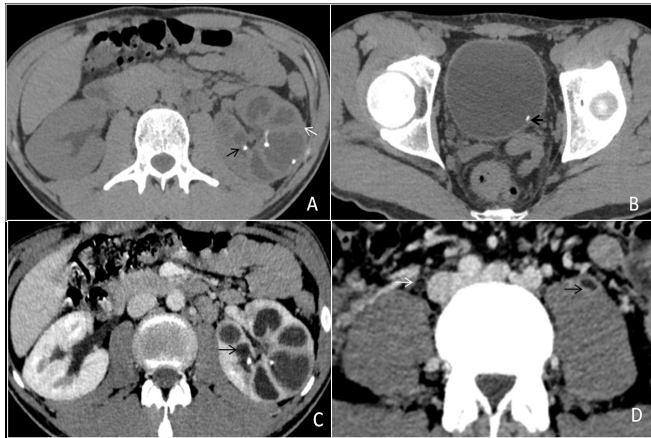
(A) A 40 years old male patient came to our hospital three months back. After initial investigations, he was diagnosed with genito-urinary tuberculosis and started on ATT, after which the patient improved symptomatically. However, after three months, he discontinued the treatment and again presented to us with burning micturition and increased frequency of urination. The patient underwent a CT scan which is depicting a relatively enlarged left kidney with fine calcification along the calyces (black arrow) and thinning of renal parenchyma (white arrow). (B) NCCT scan at the level of the urinary bladder shows a focus of calcification in the urinary bladder near the left vesicoureteric junction (VUJ) (thick black arrow). (C) CECT scan in the axial plane at the corresponding level of the image (A) shows uneven caliectasis (black arrow). (D) Axial view from the CECT scan shows both mid parts of the ureters over the psoas muscle. There is dilatation of the left ureter and thickening and enhancement of the urothelial of the ureter (black arrow). The right ureter appears normal (white arrow).
